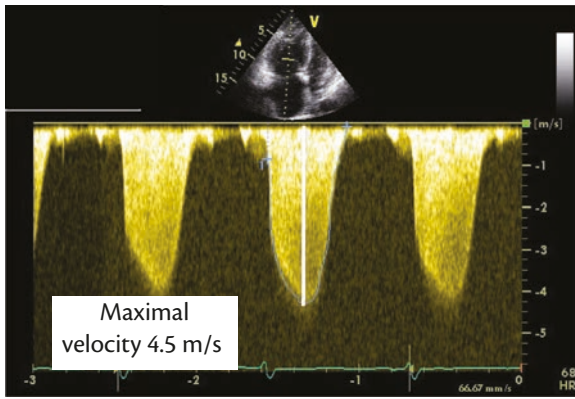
Tricuspid regurgitation recorded using continuous wave Doppler. Pulmonary artery systolic pressure (SPAP) is calculated as $4 \times (\text{Maximal velocity})^2 + \text{right atrial pressure}$. In this patient RAP = 9 mmHg and SPAP = 80 mmHg.
